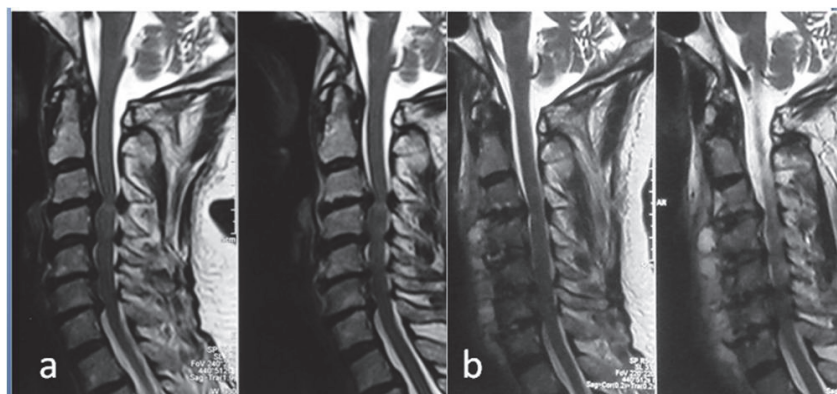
MR images of the 77 year-old female patient with radiculomyelopathy discerned high intensity signal on T2 weighted scans a), and postoperative MR images showed decompression of the neural structures. JOA score of the patient improved from 12 to 15 postoperatively (b).
